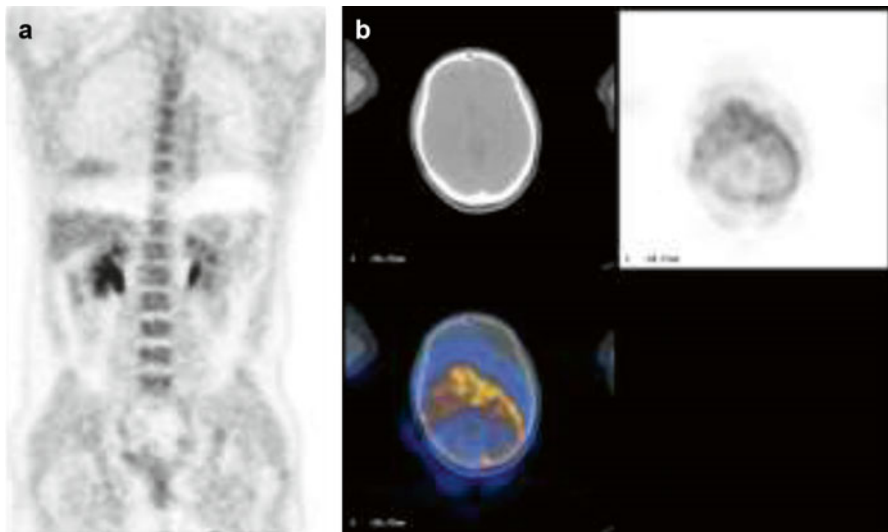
(a) Respiratory motion artefact seen at the dome of the liver caused by mismatch of PET and CT for attenuation correction. (b) Patient motion between CT for attenuation correction and PET leading to poor correction for attenuation and localisation of tracer uptake
